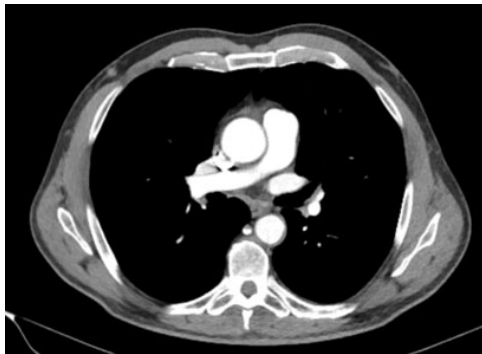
Computed tomography chest, right breast 8 mm nodule consistent with known biopsy-proven breast cancer. No evidence of metastatic spread to the lungs or lymph nodes.
